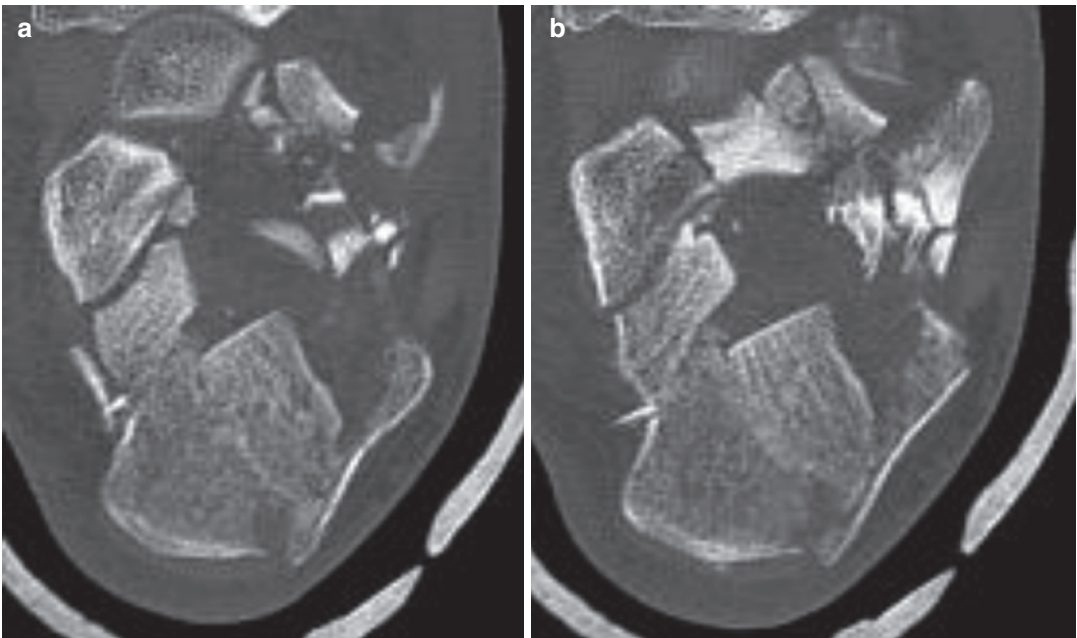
Axial CT images
